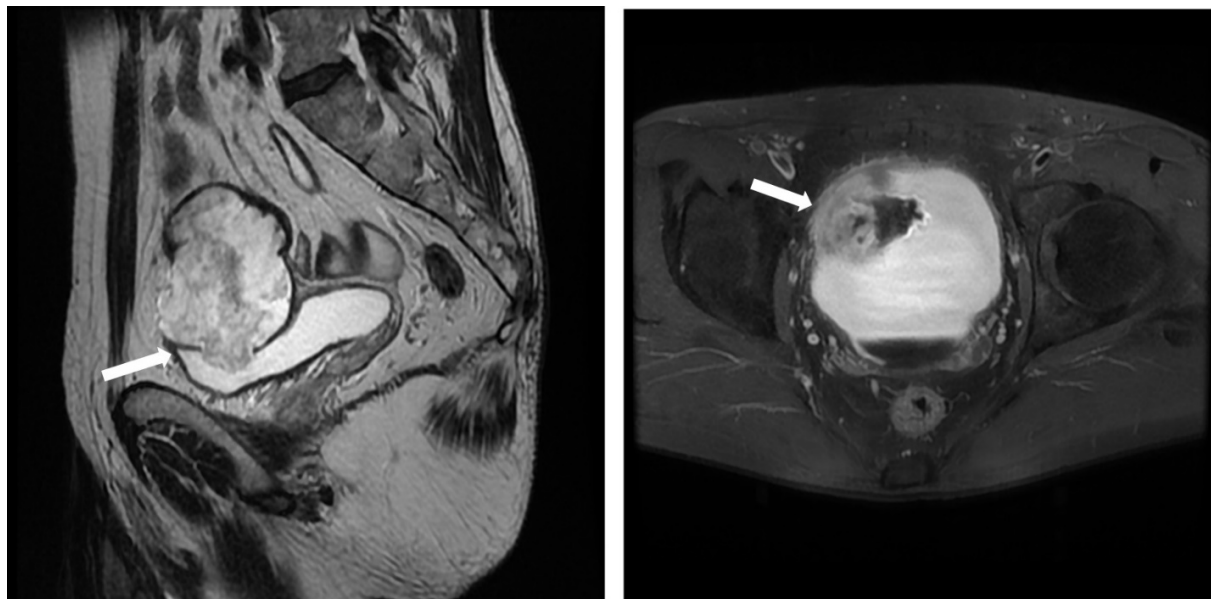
MRI image sagittal and transverse
